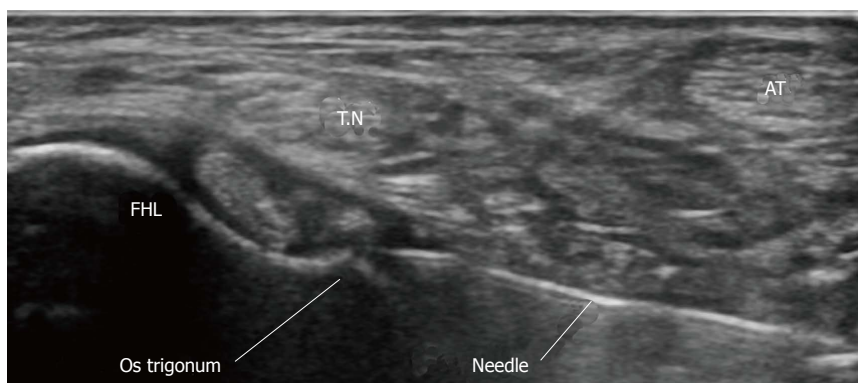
Ultrasound guided diagnostic injection. AT: Achilles tendon; FHL: Flexor hallucis longus tendon; T.N: Tibial nerve.
